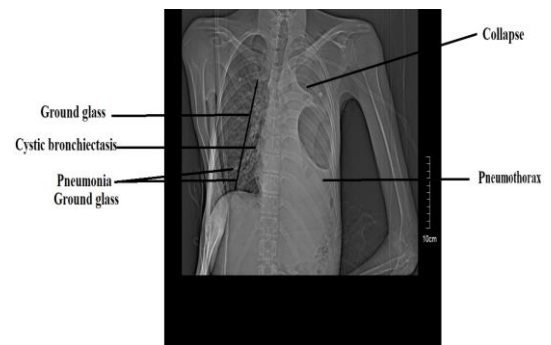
Initial CT scan findings in the patient suffering from multiple sclerosis with a lung infection.
